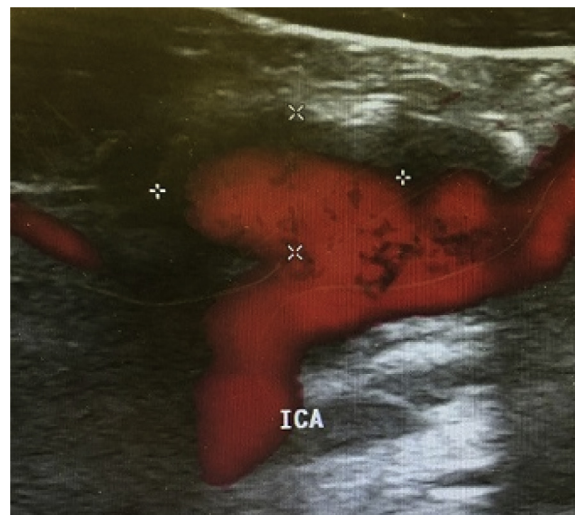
Duplex ultrasound (DUS) image of post-carotid endarterectomy (CEA) right carotid artery pseudoaneurysm (CAP). ICA, Internal carotid artery.
